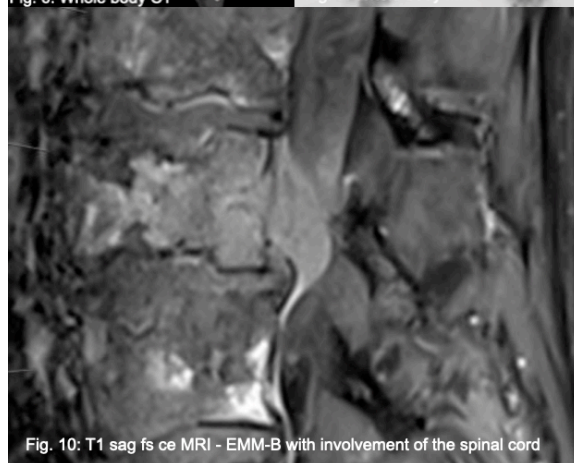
T1 sag fs ce MRI - EMM-B with involvement of the spinal cord
